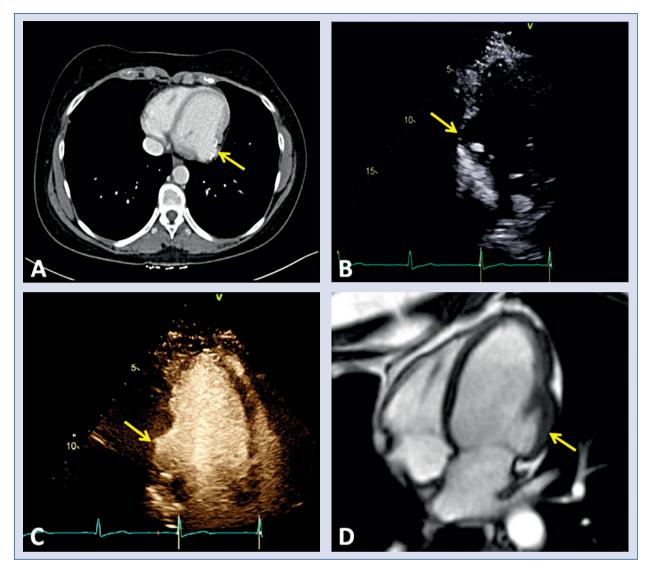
An abdominal computed tomography scan (A), transthoracic echocardiography (B, C), and cardiac magnetic resonance imaging (D) showing a left ventricular outpouching typical of a congenital diverticulum.
